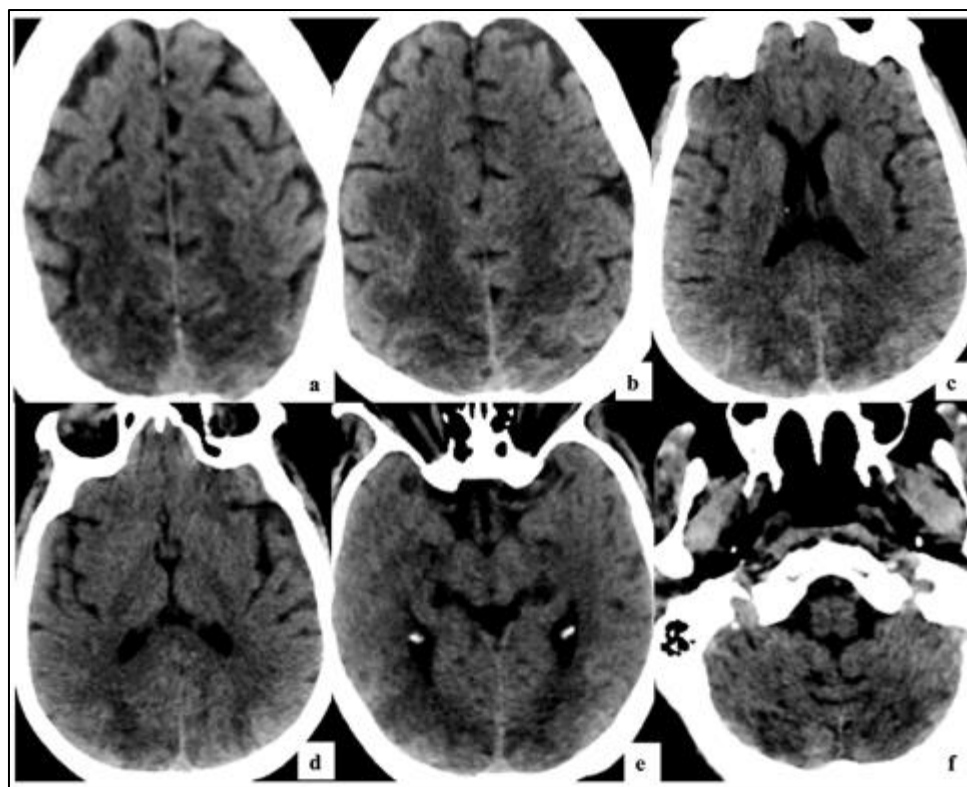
(a – f). Axial non-contrast CT scan images : Follow-up day 14 head CT shows slightly increased cerebral edema, with no obvious hemorrhage
